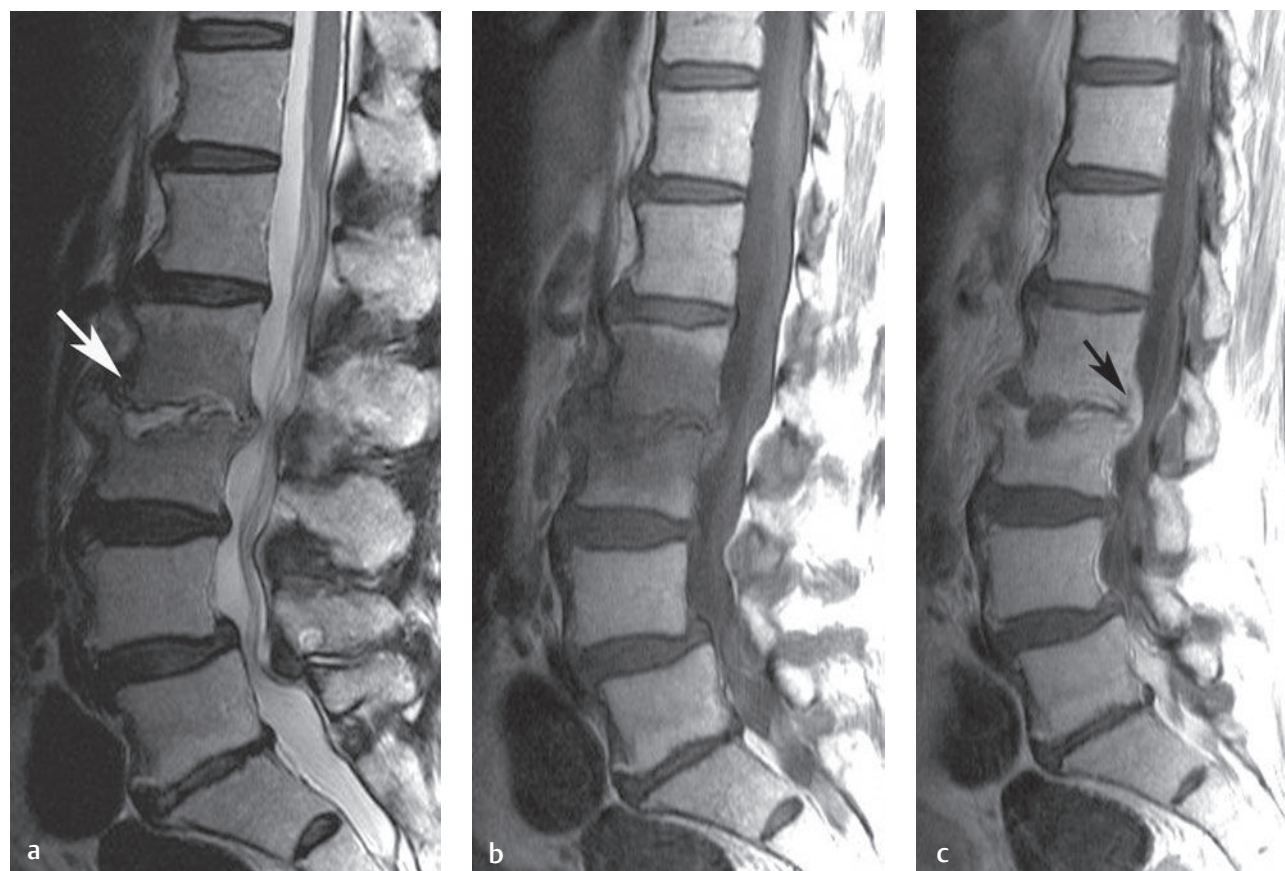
Discitis. Sagittal (a) T2-weighted, (b) T1-weighted, and (c) postgadolinium T1-weighted images show the typical findings of discitis at the L2-L3 level (arrows on a and c). Note the increase in signal at the disc space on the T2-weighted image, the decrease in signal on the T1-weighted image, and the postgadolinium enhancement of the small epidural component (c, arrow).[†]
